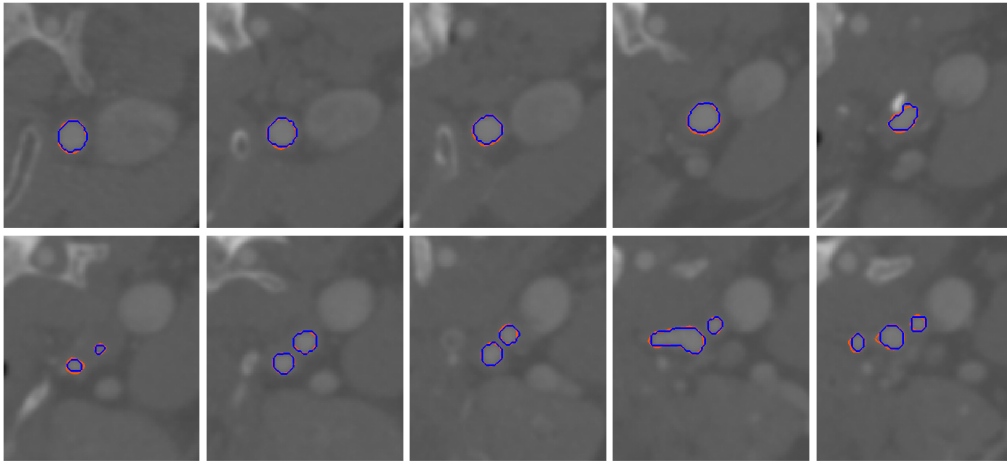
Comparison of geometry segmented from CT image dataset 3 using image slices taken along z-axis direction: blue - manual, orange - GPF deformable model.
